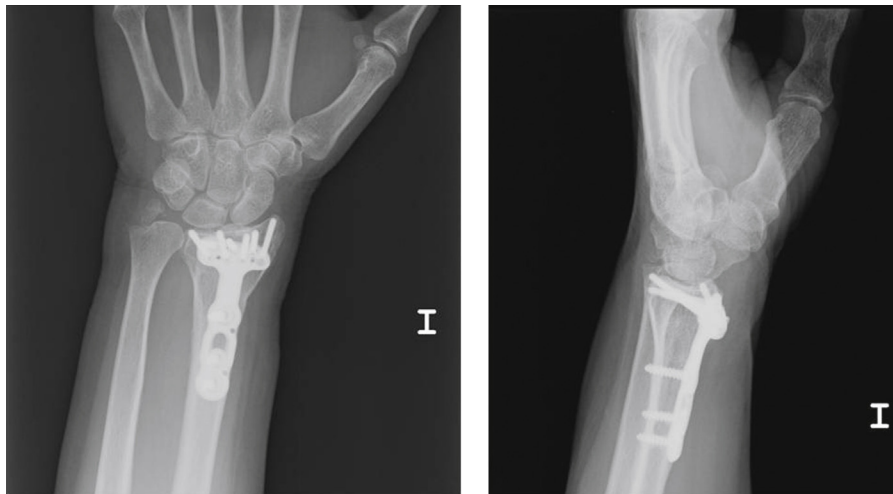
Radiographic projections with correcting supports. The slight protrusion of screws at the intra-articular and dorsal levels can be observed.
